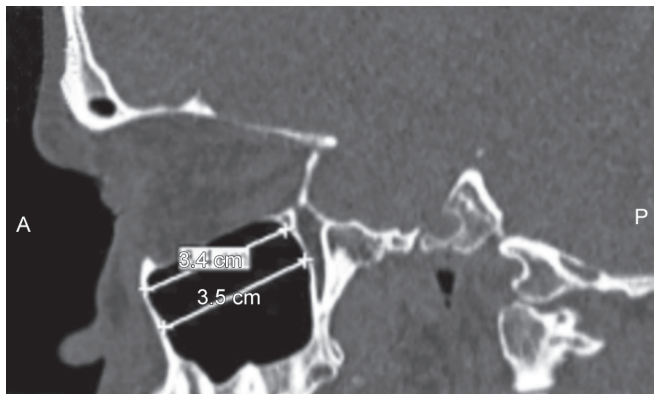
Sagittal section of maxillary antrum CBCT image showing maximum AP dimension
